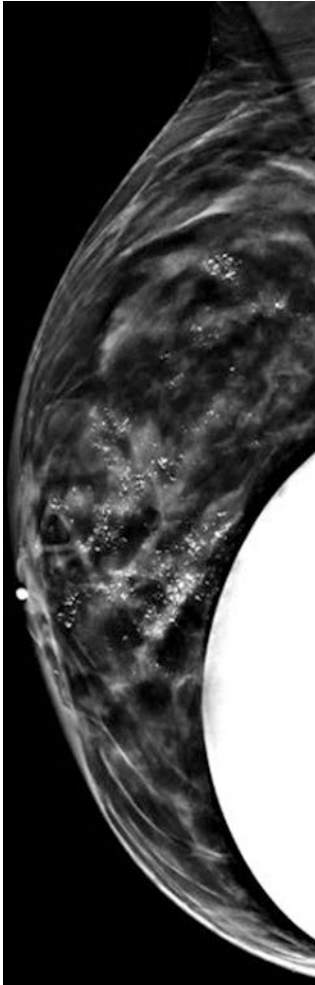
Radiographic microcalcifications from DCIS on mammography in a patient with a prior implant
